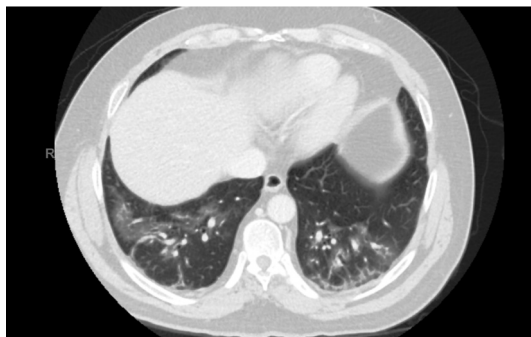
Contrast-enhanced CT of the chest. Multifocal patchy ground-glass opacities throughout both lungs in a patient with COVID-19 who presented with a renal infarction.
